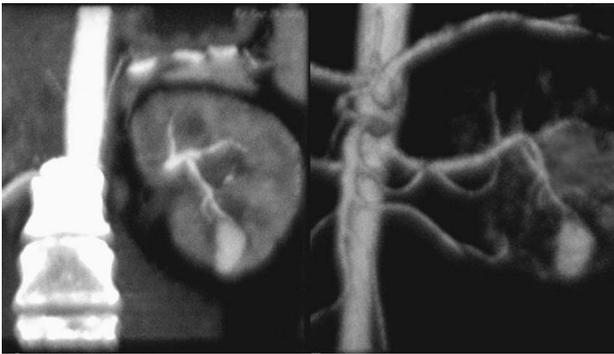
Left, Angio-CT demonstrates the pseudoaneurysm (arrow) in the lower pole of the left kidney. Right, 3-D Reconstruction following angio-CT shows the pseudoaneurysm (arrow) arising from the lower polar segmental artery.
